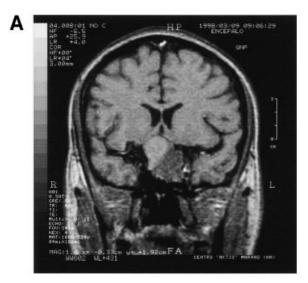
Magnetic resonance imaging with coronal sections of another example of macroprolactinoma (no. 35, Table 1) (A) before and (B) after six months treatment with cabergoline at a dose of 0.5-3 mg/ week.
